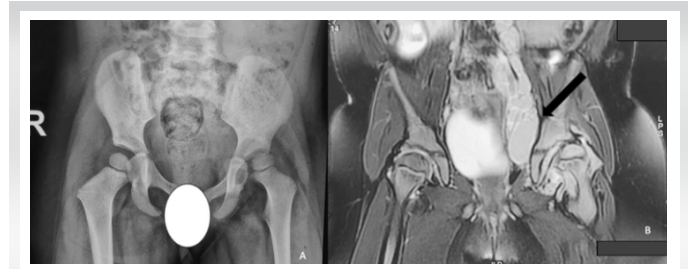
Two-year child came with complaints of pain and limitation at left hip joint for past 5 days. A. Subluxed hip joint left side due to septic effusion. B. MRI showed additional collection along the left psoas muscle extending into the left hip joint (marked by arrow).
